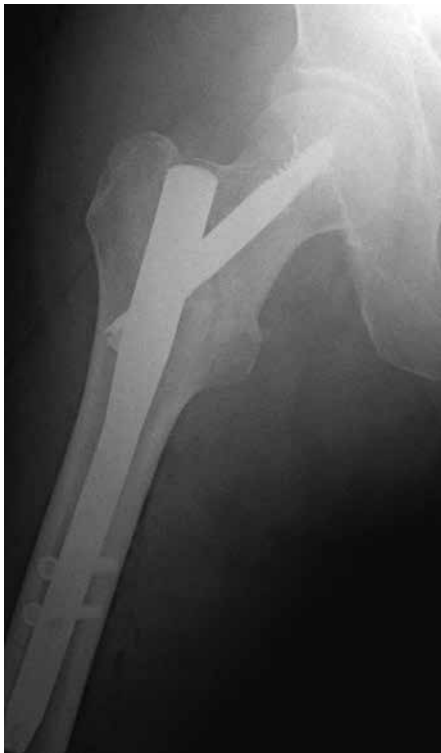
Post-operative lateral radiograph of the same patient's right hip.
